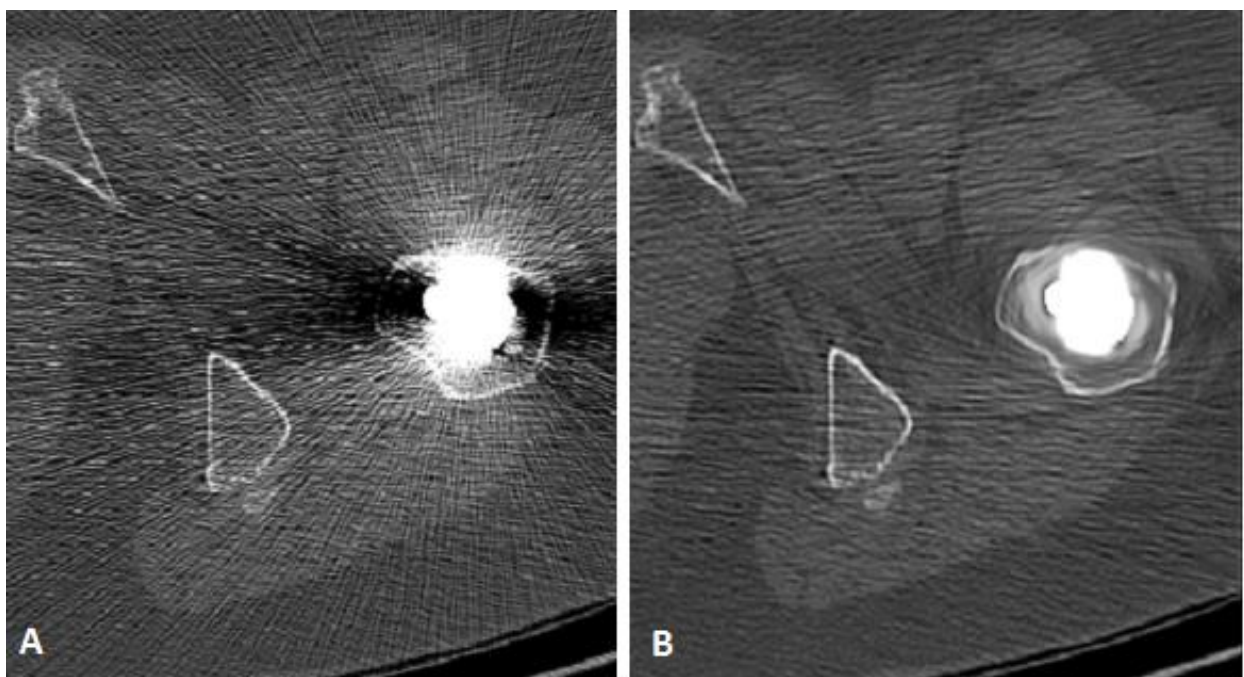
A) CT-slice of a THA patient post-surgery, filled with artifacts from the metal hip stem. B) After the reduction the artifact streaks are no longer there.
